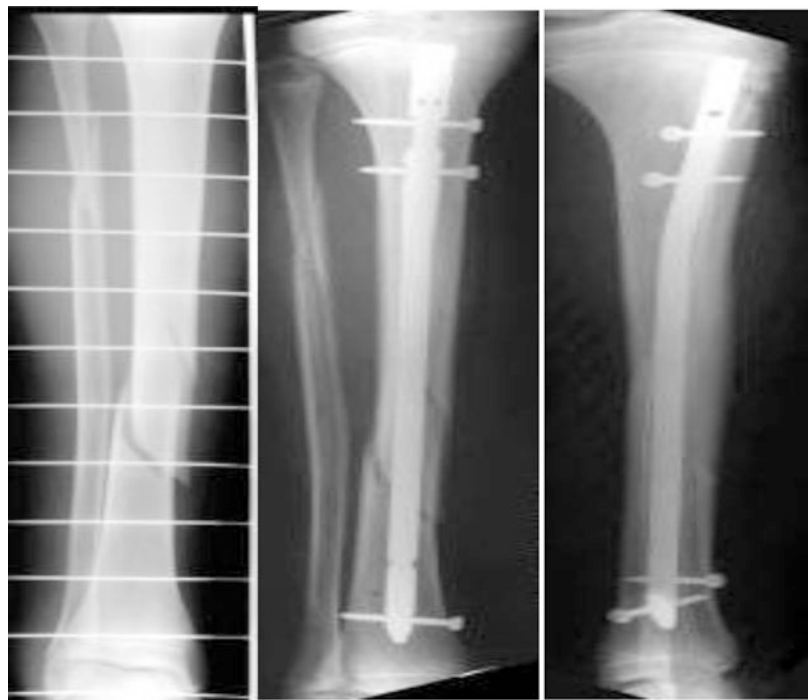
X-rays of Tibia fracture treated with intramedullary locking nail
